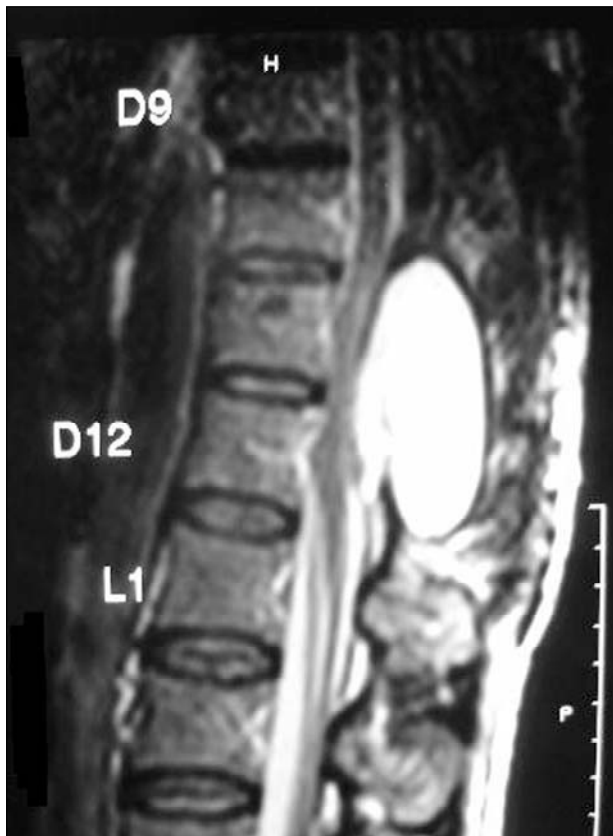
T2-weighted sagittal spinal MRI demonstrates large CSF collection at T11-T12 levels.
